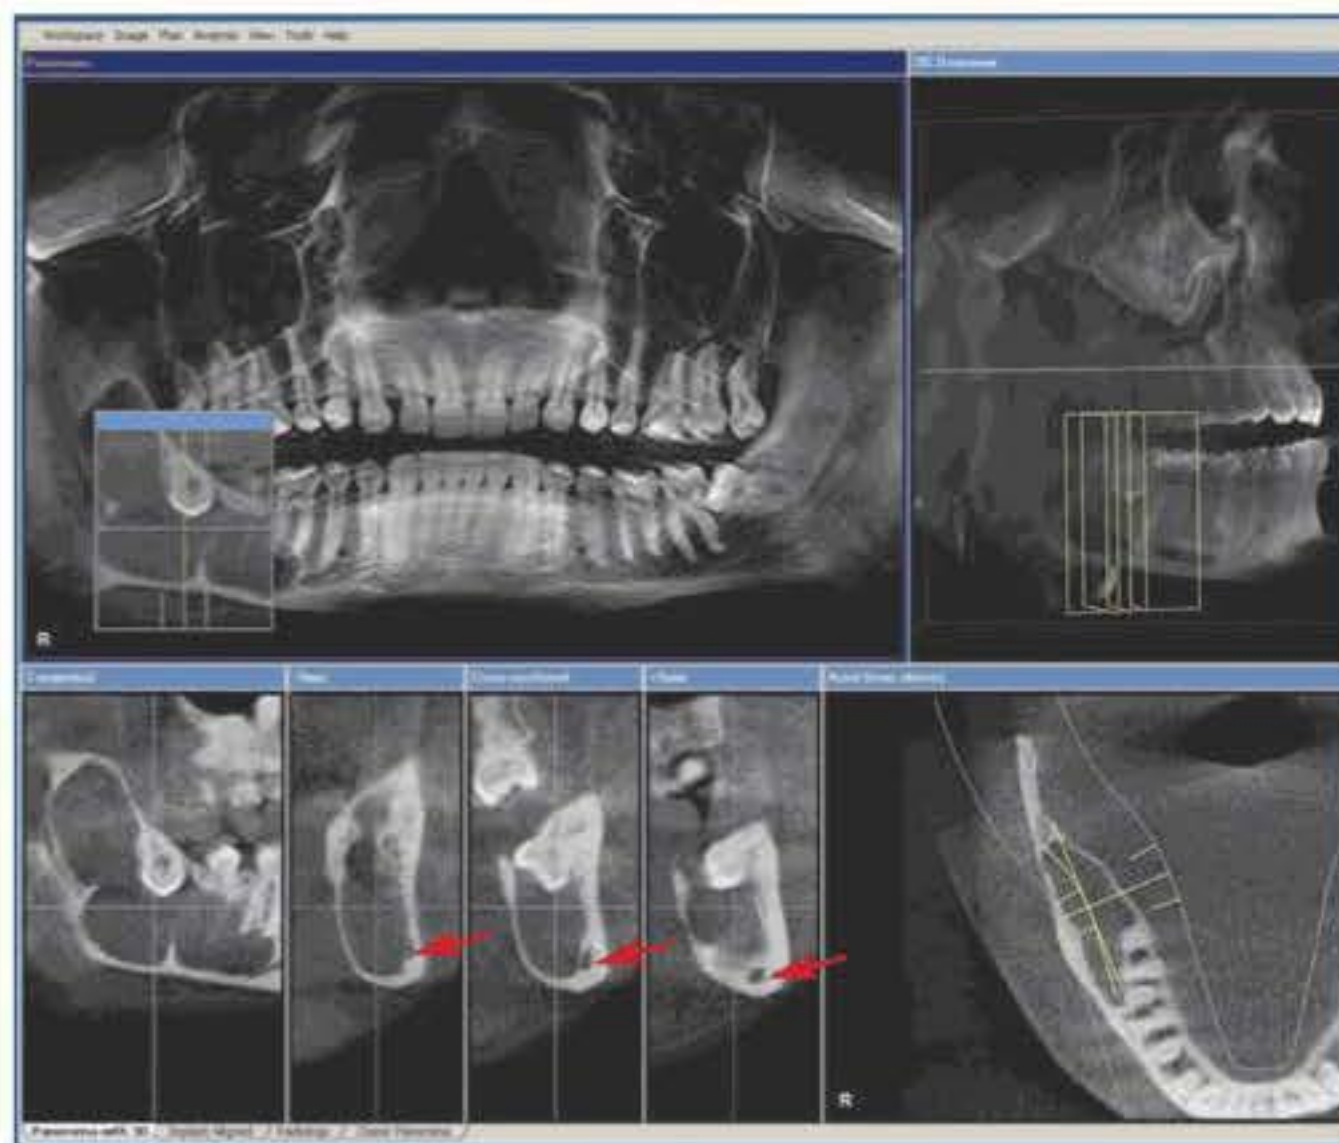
Cone-beam volumetric imaging of the same patient as in Figs 5-7 and 5-8, more than four and a half years later. Both the buccolingual and the craniocaudal expansion of the keratocyst in the region of 48-46 can be clearly identified. The inferior alveolar nerve (arrow) can be identified in the transverse and tangential slices.
